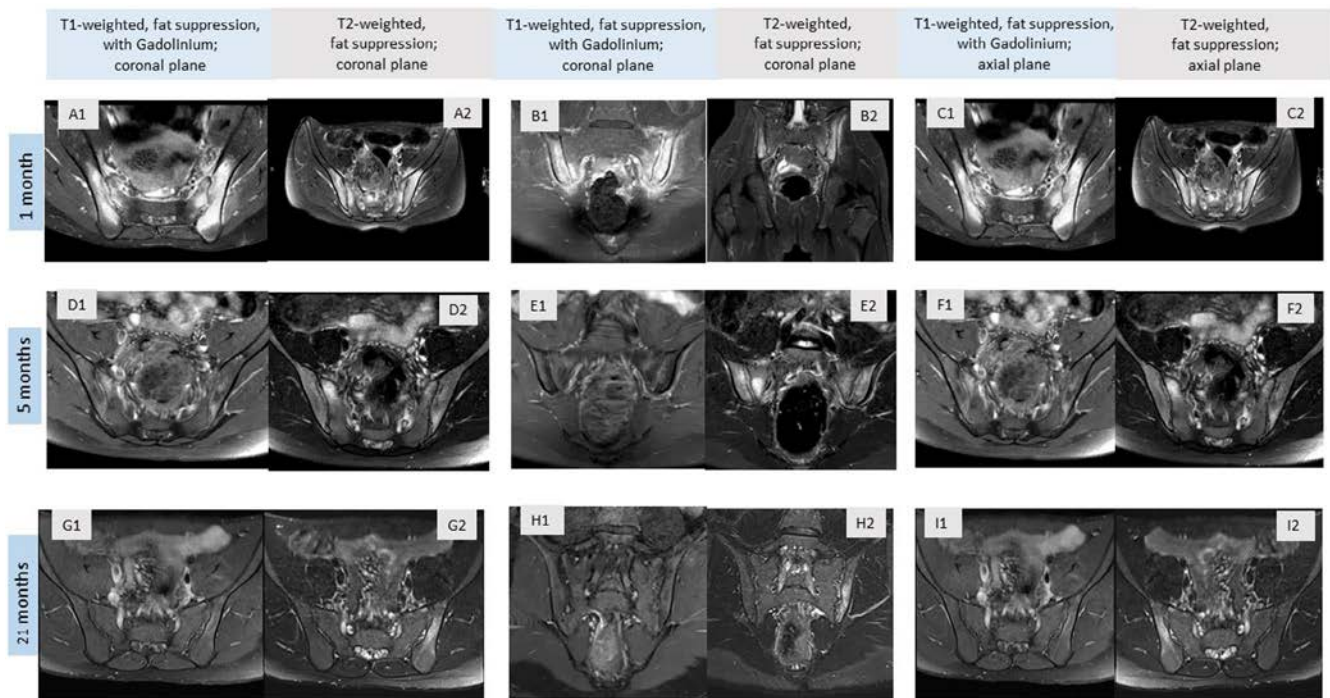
Isotretinoin-induced sacroiliitis over time. Coronal and axial T1-weighted MRI images (T1; labeled as 1), fat-suppressed (FS) post-contrast images, and T2-weighted FS scans (T2; labeled as 2) obtained 1 month after clinical presentation (Panels A, B, C) showed bilateral subchondral bone marrow edema at the sacroiliac joints, along with soft tissue edema (post-traumatic) anterior and posterior to the joints, involving the gluteus minimus abductor muscles. Two follow-up studies demonstrated gradual resolution of these findings at 5 months (Panels D, E, F) and 21 months, with minimal bone marrow edema still visible in the iliac bone after a prolonged period following isotretinoin cessation (Panels G, H, I).
